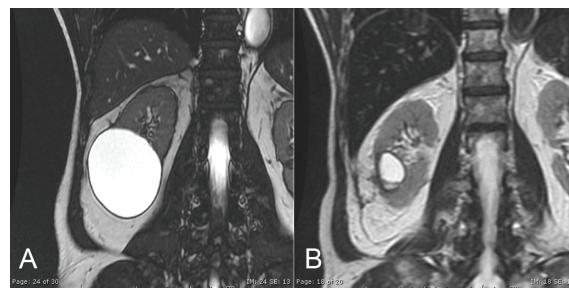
Preoperative abdominal imaging (magnetic resonance imaging; MRI) (A) of a 74-year-old man with a simple renal cyst, about 9 cm in diameter, located in the lower pole of the right kidney. His MRI (B), 10 months after LESS laparoscopic cyst resection using Starion scalpel, revealed procedural success
